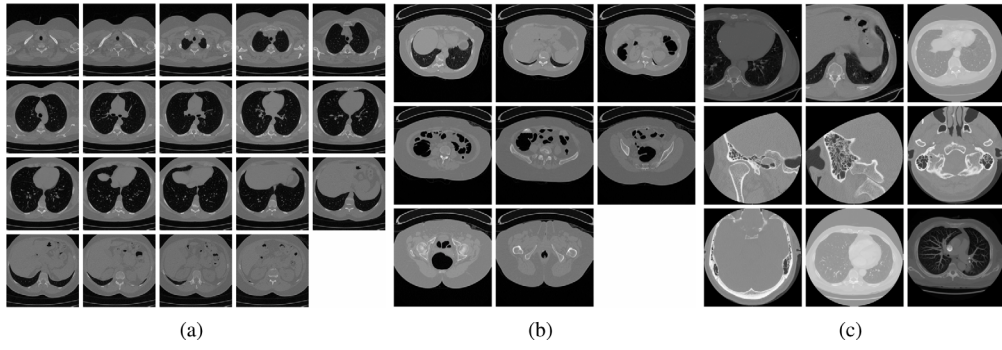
Sample images of the used datasets. Each image corresponds to one category. (a) 19 images from the EXACT09-CT dataset. (b) 8 images from the TCIA-CT dataset. (c) 9 images selected from the NEMA-CT dataset.
